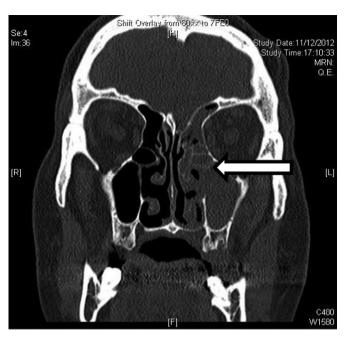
Coronal CT image without contrast showing thickening of mucosa and opacification of left ethmoidal and maxillary sinuses (indicated by the arrow).
